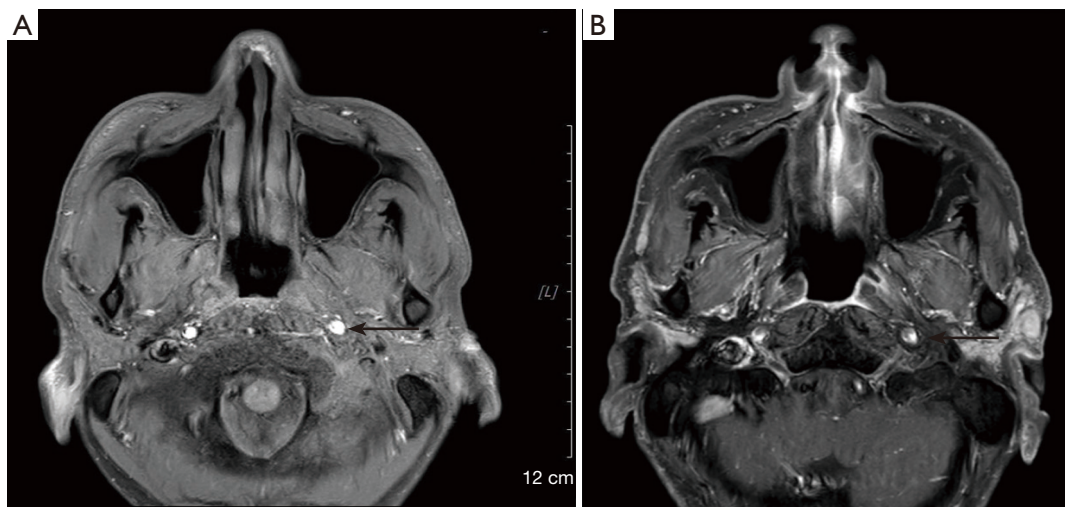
Response of the main lesion estimated by computed tomography. (A) After 2 cycles, the tumor was significantly smaller than before, and partial enhancement was shown by enhanced MRI. The arrow indicates the tumor area. (B) Enhanced MRI examination indicated that the tumor continued to show a CR on January 7, 2020. The soft tissue of the nasopharynx was slightly thick, the left pharyngeal recess was narrowed, and the bone structure of the left skull base was disordered. The arrow points to the area where the tumor disappears. MRI, magnetic resonance imaging; CR, complete response.
